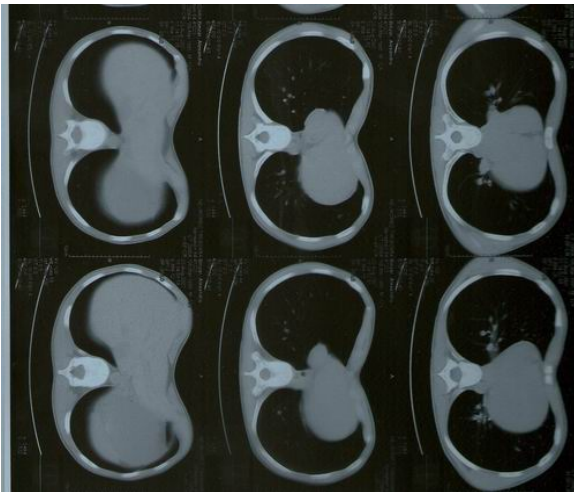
CT scan - anterior indentation of the right ventricle.
